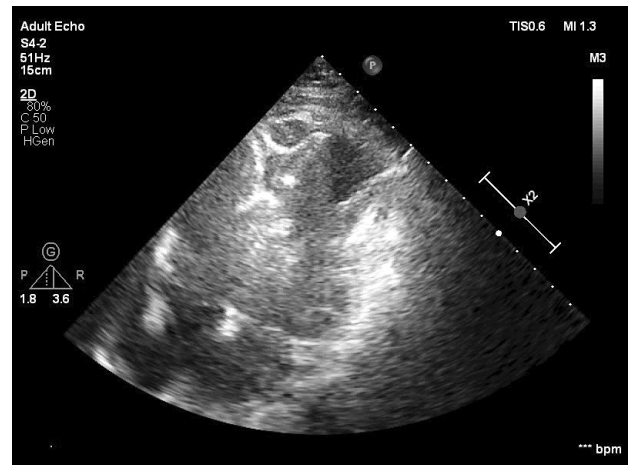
Echocardiogram with device
